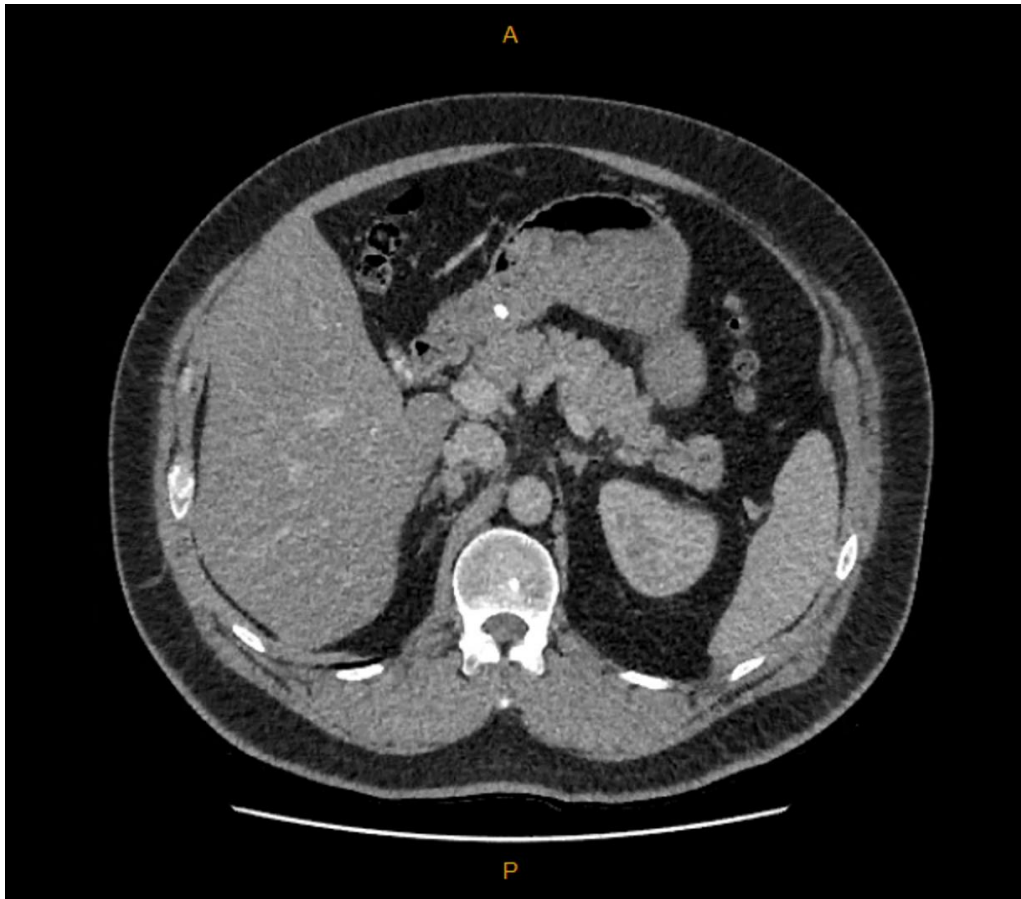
CT of the adrenals
